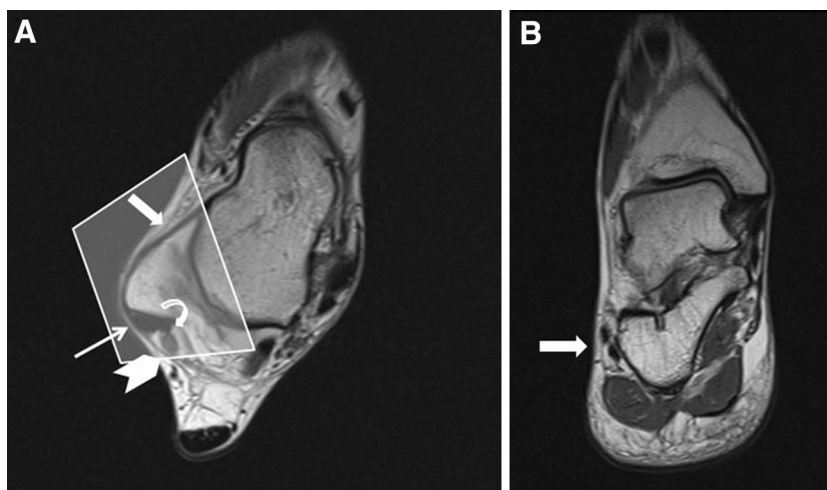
Axial proton density (PD)-fat suppression (FS) MR image: The lateral compartment of the ankle contains the peroneus longus (*curved arrow*) and peroneus brevis (*thin arrow*) tendons (at the retromalleolar level, the former runs posterior to the latter); the anterior fibulotalar ligament, which stretches from the lateral
